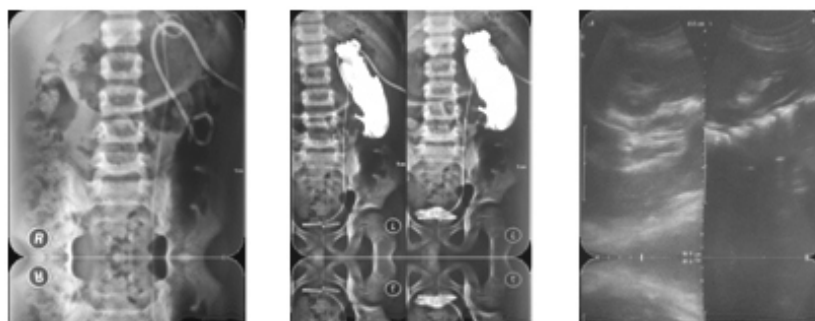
Left APG and left kidney ultrasonography postoperative.
